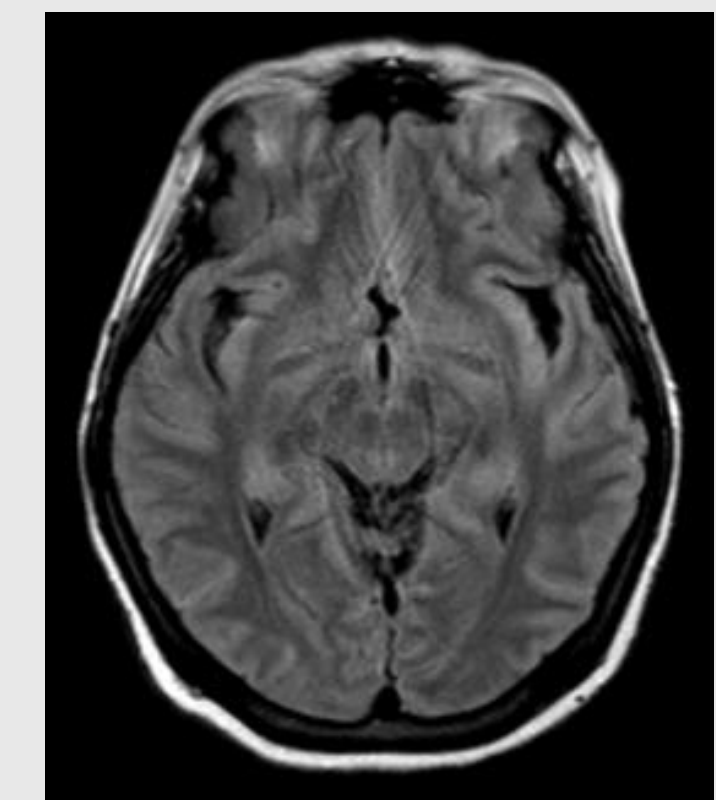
MRI brain showed isolated subtle signal change involving bifrontal cortex which may represent hypoxic-ischemic change
